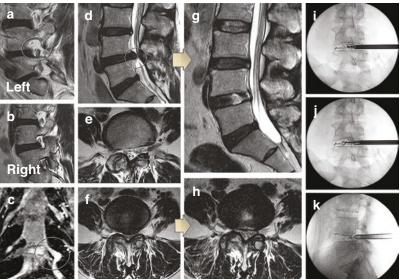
Contralateral approach of TELD in case of conjoined nerve root. A preoperative MRI of a 54-year-old female patient with radiating pain in the left lower extremity showed left intracanal disc herniation (\mathbf{d}, \mathbf{f}) and left conjoined nerve root (a, c, e) at L4–5 level, and the right side showed normal nerve travel (b). Complete removal of the herniated disc and successful decompression (g, h) was achieved by performing TELD with a contralateral approach (i, j, k)
